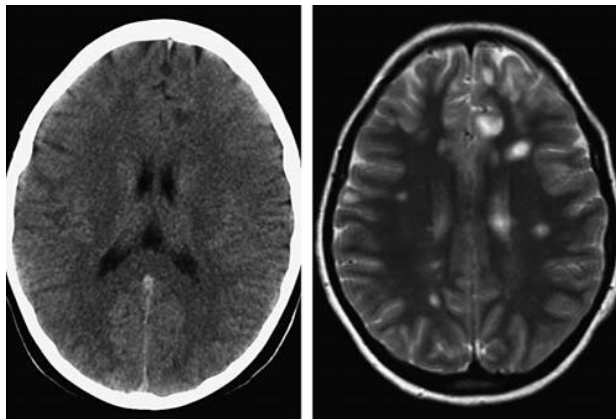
White matter lesions are very difficult to detect in CT (left) compared to MRI (right). Reproduced from Barkhof & Scheltens (2002).
